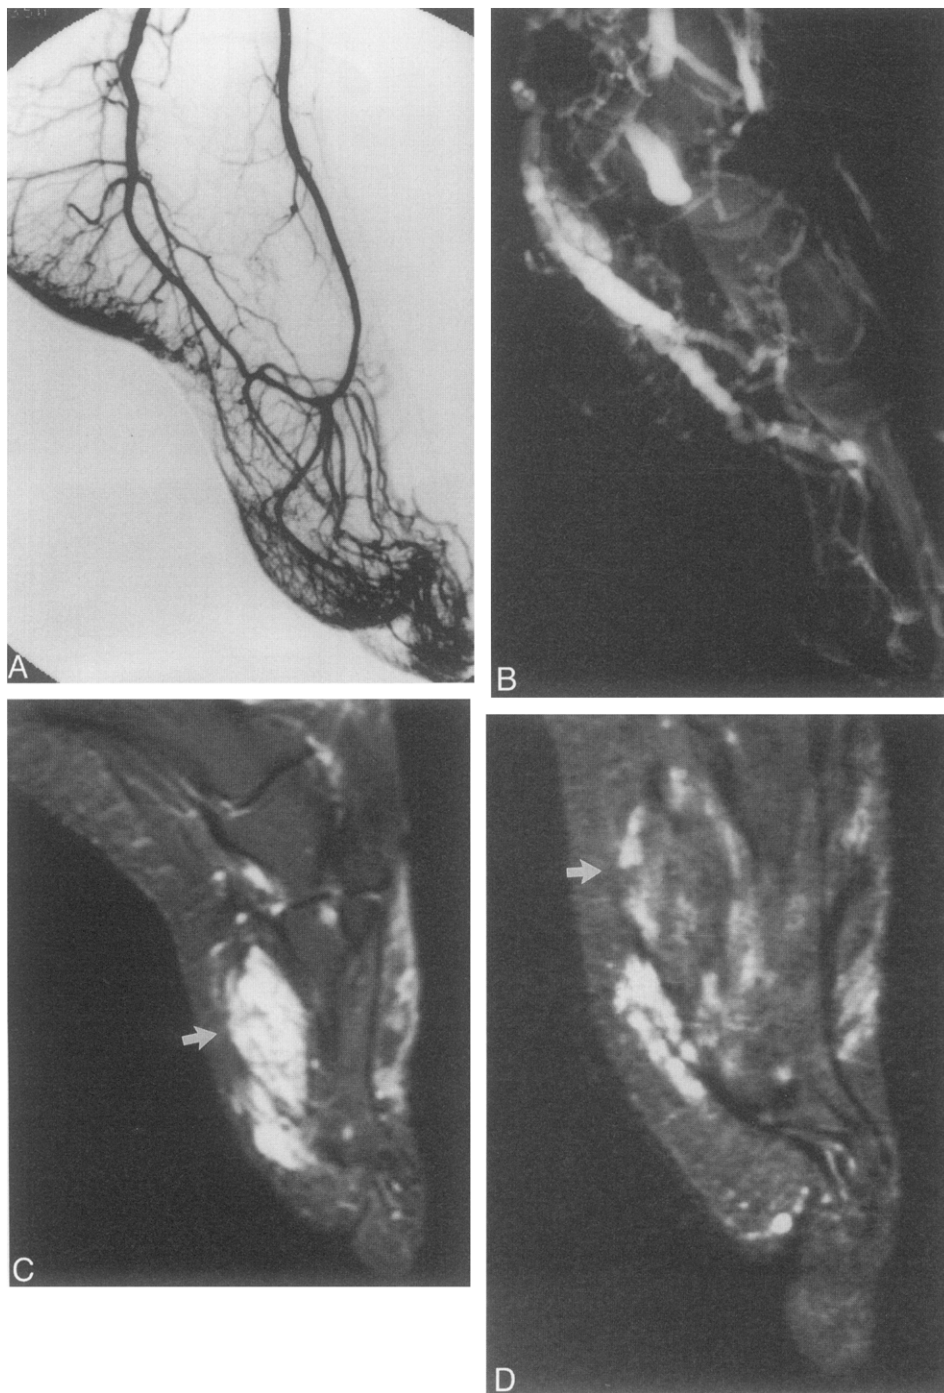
Various imaging methods in a patient with VM of the left foot. A, Normal arteriogram; B, normal venogram. C, VM between the fourth and fifth metatarsals as a hyperintense (white) signal on this T₂ MRI image (*arrow*). D, T₂ MRI image demonstrates the same area as C 1 month after direct injection of ethanol into the lesion (*arrow*). Notice the greatly decreased size of the VM as well as the residual soft tissue swelling from the procedure.
